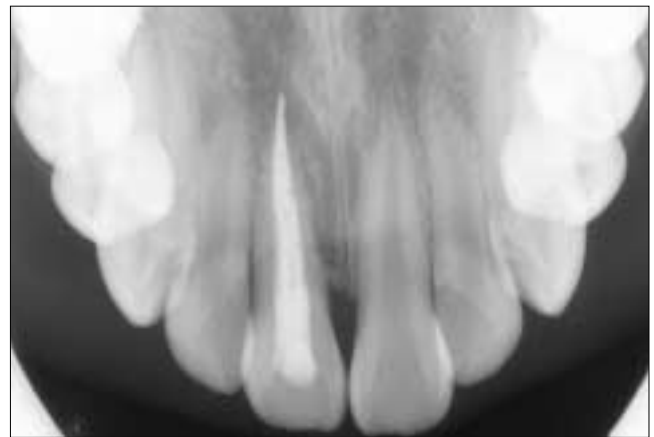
Radiograph taken 2 years after replantation. Replacement root resorption of tooth 11 is obvious.
